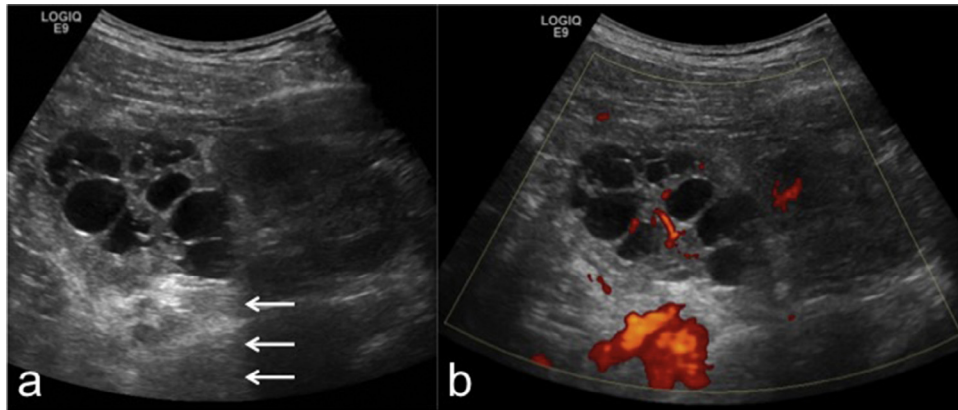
B-mode ultrasound (A) and power Doppler (B) of the left kidney showing a multilocular cystic lesion in the upper pole. A normal-appearing lower pole renal parenchyma is seen. The cysts are anechoic, and there is a posterior acoustic enhancement (arrows). The renal parenchyma between the cysts is hyperechoic with evidence of vascularity on Doppler.
